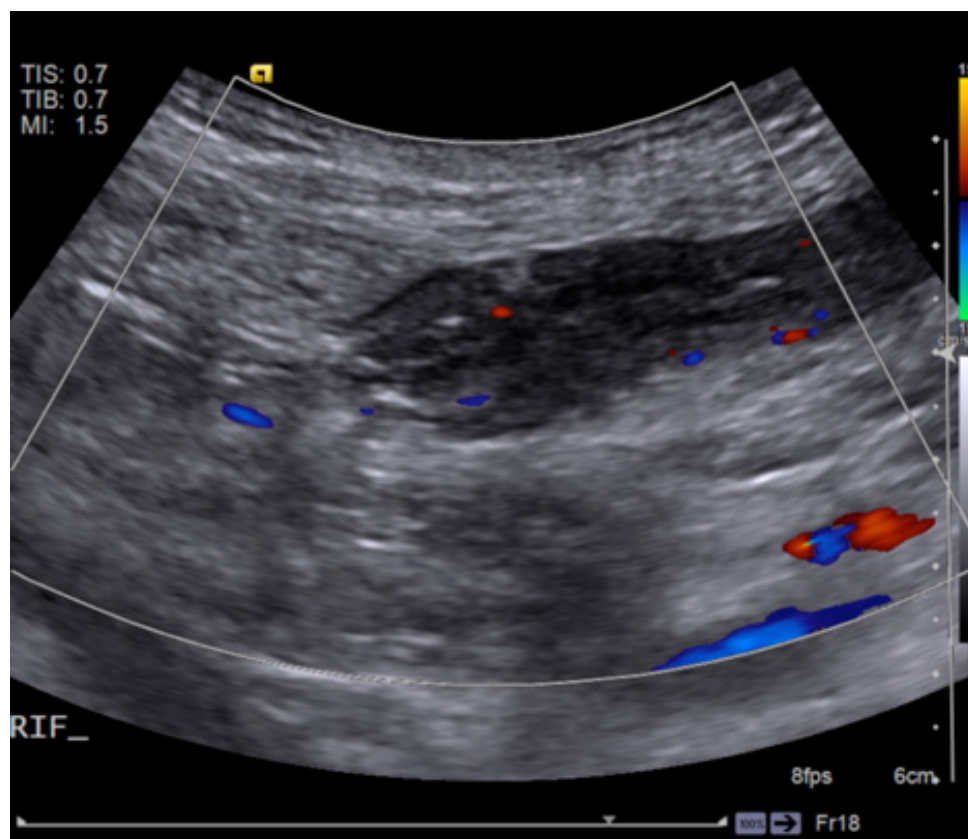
Curvilinear ultrasound of the right iliac fossa demonstrating thickening and oedema of the terminal ileum, with associated moderate hypervascularity on colour Doppler.
